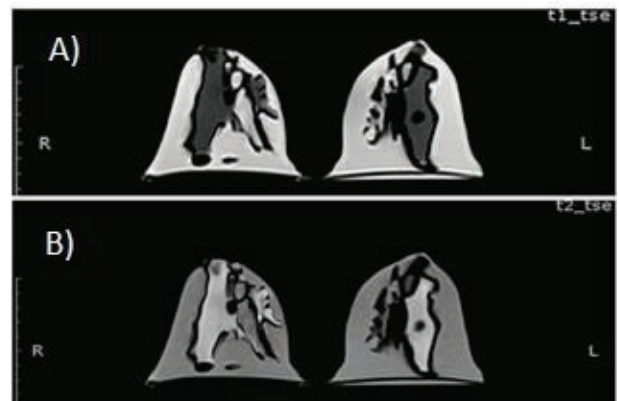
MR images of the personalized 3D-printed breast model. (A): T1-weighted image. (B): T2-weighted image using turbo spin echo (TSE) pulse sequence. Reprinted with permission under the open access from Sindi et al.²⁰
